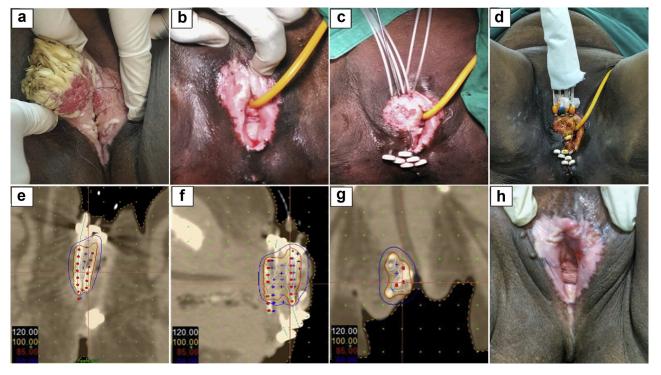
Panel showing the pictures and dose distribution of a typical freehand HDR interstitial vulvar brachytherapy and outcome at 3 months. a, at presentation; b, post external radiation; c and d, catheter placements; e, f, and g, representative axial, sagittal, and coronal CT images with isodose distributions; h, post treatment 3-month follow-up outcome.
